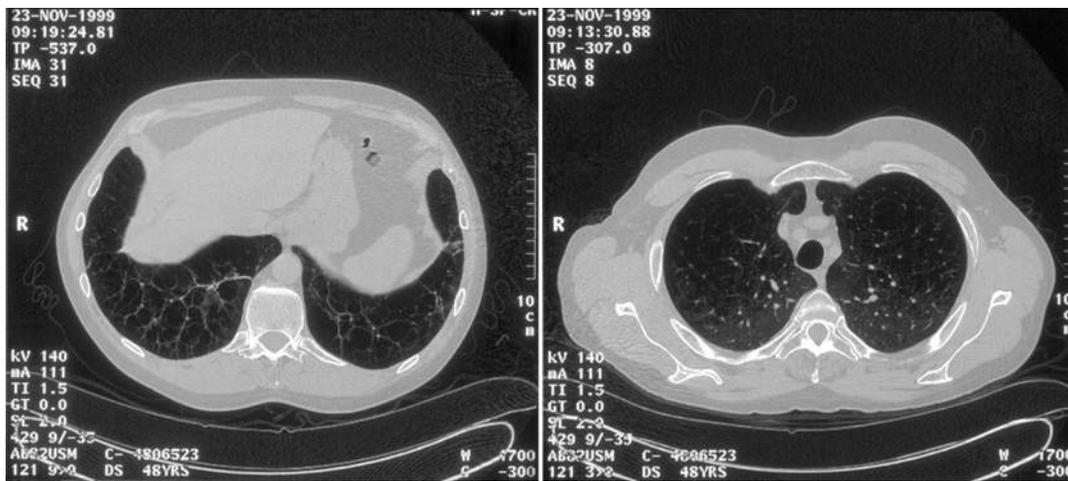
Computed tomography chest image from an individual with severe deficiency of alpha-1 antitrypsin. Note the changes of emphysema (arrows) are more pronounced in the lung bases (B) than in the lung apices (A).
